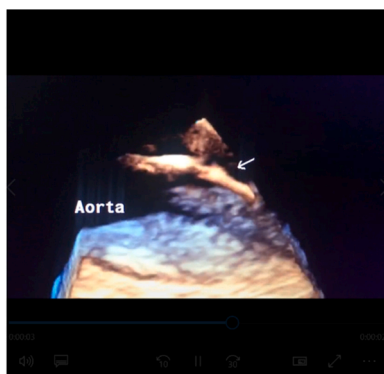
Wire-shaped mass (arrow) in the thoracic aorta in Trans-esophageal echocardiography.
